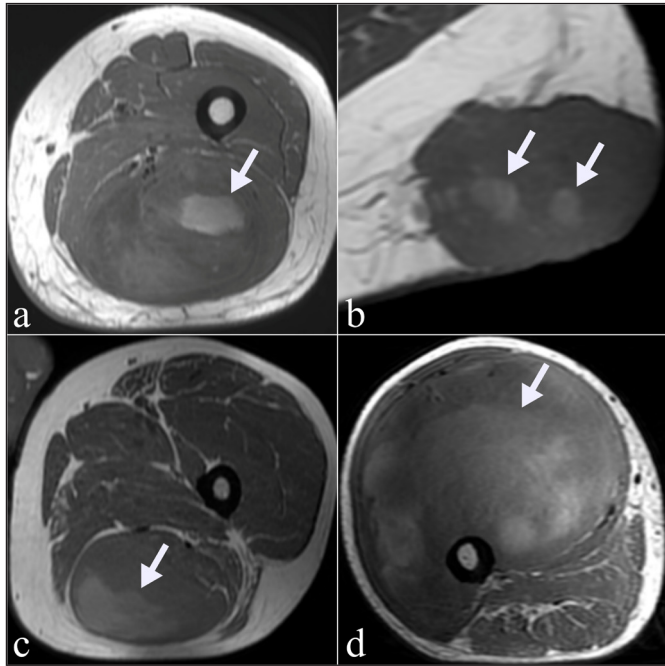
The presence of hemorrhage signal distinguished as a hyperintense signal on T1W is an important indicator for high grade. a. In the thigh MRI of a 41-year-old male patient, pleomorphic sarcoma and the hemorrhage area within the tumor were shown with an arrow. b. In the pelvic MRI of a 28-year-old female patient, angiosarcoma and the hemorrhage area within the tumor were shown with arrows. c. In the thigh MRI of a 40-year-old male patient, undifferentiated pleomorphic sarcoma and the hemorrhage area within the tumor were shown with an arrow. d. Right thigh MRI of a 50-year-old male patient showed myxofibrosarcoma and hemorrhage areas within the tumor with arrows.
